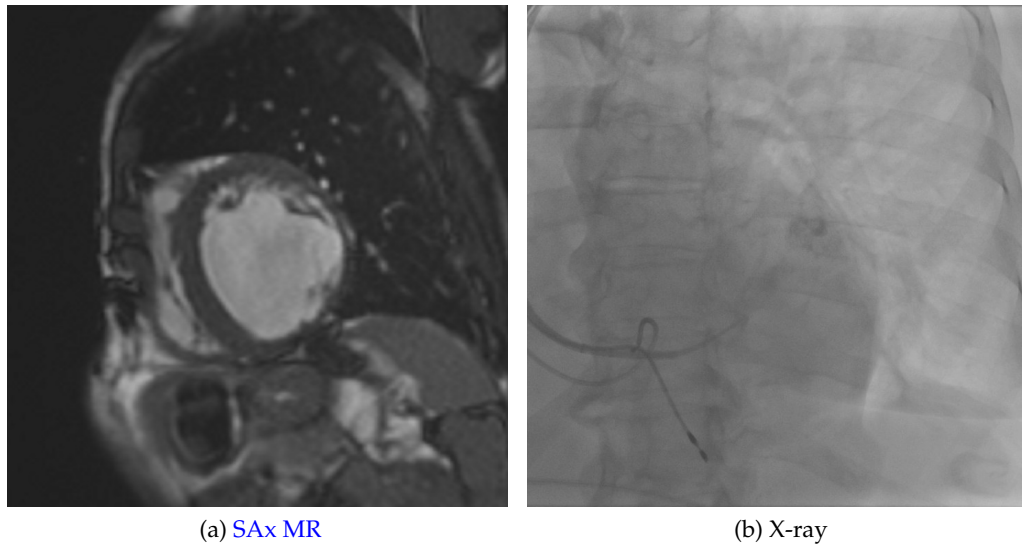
Difference in appearance of the heart in MR and X-ray images. (a) Cine MR acquisition frame of a SAX slice. (b) Interventional X-ray acquisition frame.
